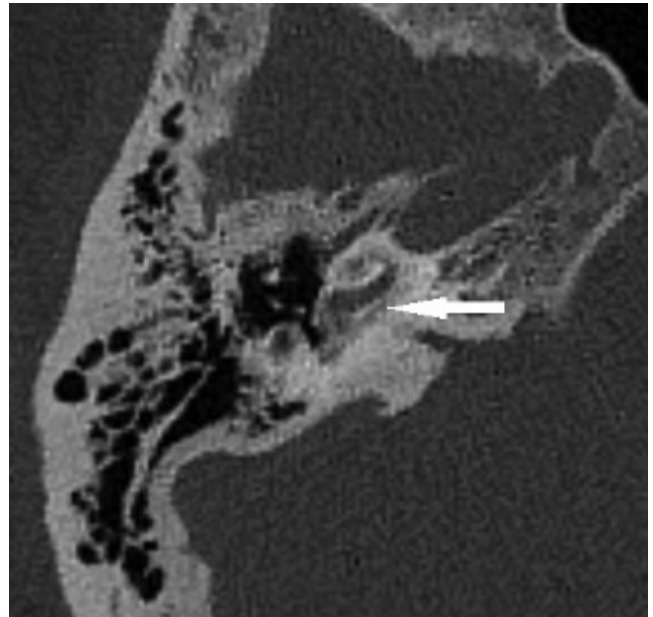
Axial CT at the level of the basal turn of cochlear shows low density surrounding the cochlea (arrow), indicating retrofenestral otosclerosis.
